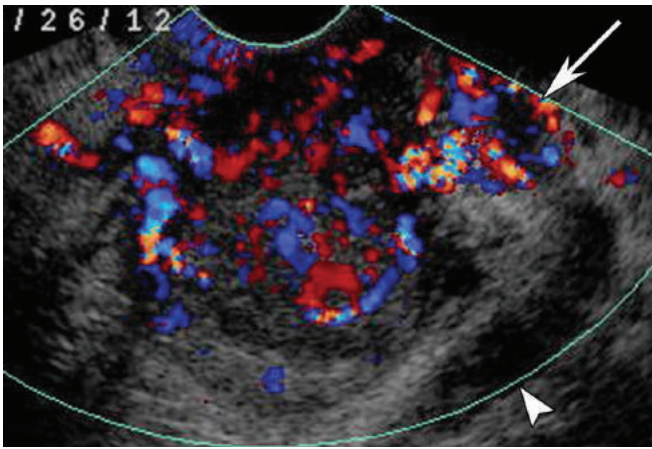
Coronal endovaginal Doppler ultrasound showing a hypervascular tumour with parametrial invasion (arrow) and obstruction of the left ureter (arrowhead).
